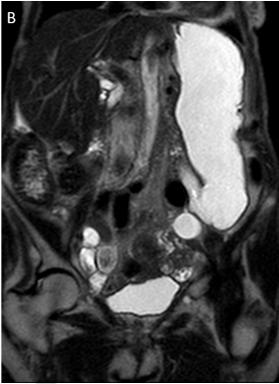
Axial plane of abdominal CT (A) showing narrowing of the third duodenal portion (approximate caliber of 3.7mm) between the aorta artery (red arrow) and the superior mesenteric artery (yellow arrow). Sagittal plane of entero-MRI (B) showing a great retrograde gastric distension due to duodenal compression.
